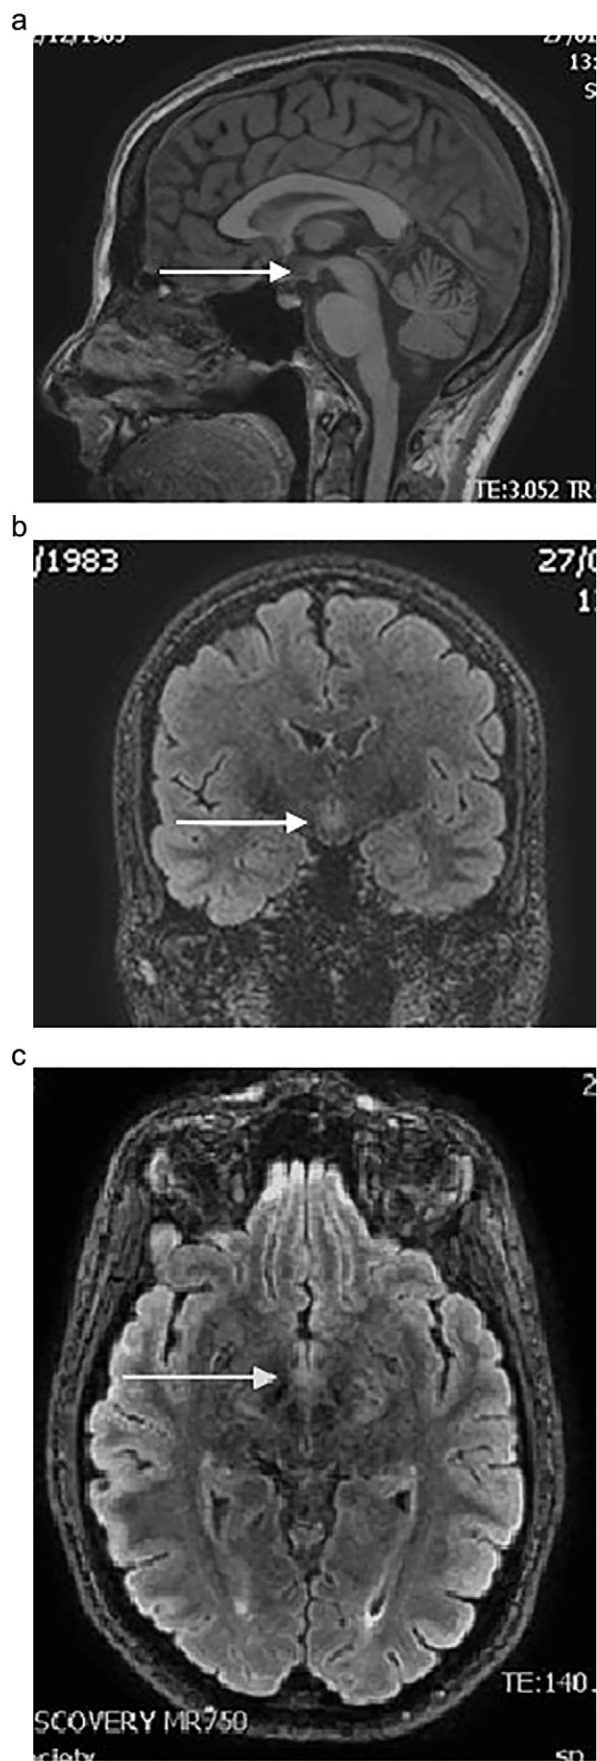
a: T1 sagittal image showing the HH which appears as a slight hypointense lesion above mammillary bodies. b: T2 FLAIR coronal image showing the HH which appears hyperintense. c: T2 transverse images showing the HH.
